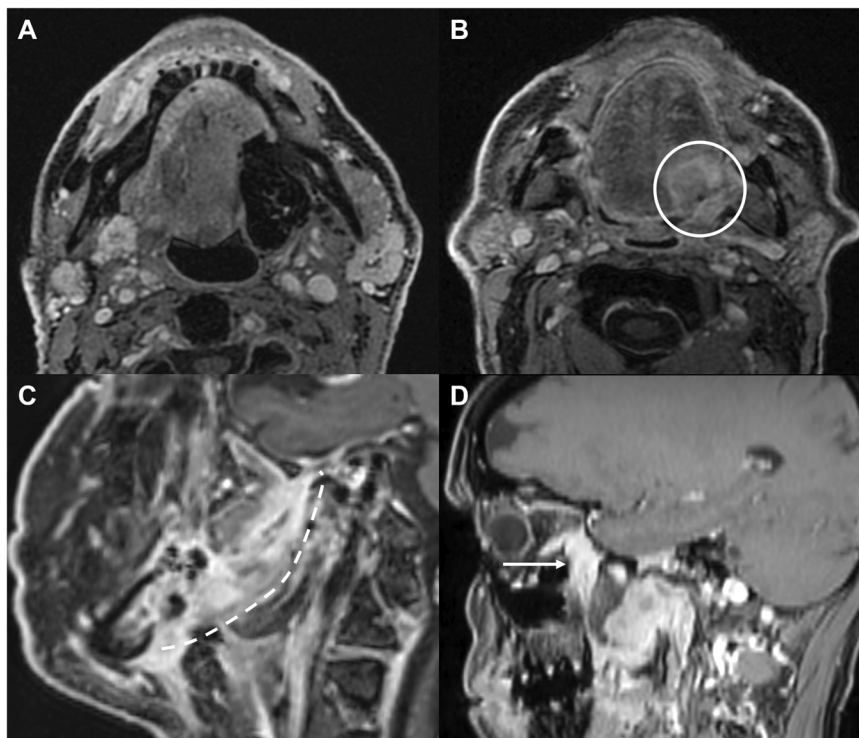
Examples of findings in T1-weighted images after GBCA administration during follow-up. A Left oropharyngeal tumor surgically removed with flap reconstruction, showing no evidence of macroscopic recurrence. B Recurrence of a left base tongue tumor (circle). C Recurrence of a retromolar trigone tumor along the pterygomandibular raphe (dashed line). D Recurrent nasopharyngeal carcinoma reaching the pterygopalatine fossa (arrow) with centrifugal PNS along the infraorbital and greater palatine nerves. GBCA, gadolinium-based contrast agents; PNS, perineural spread
